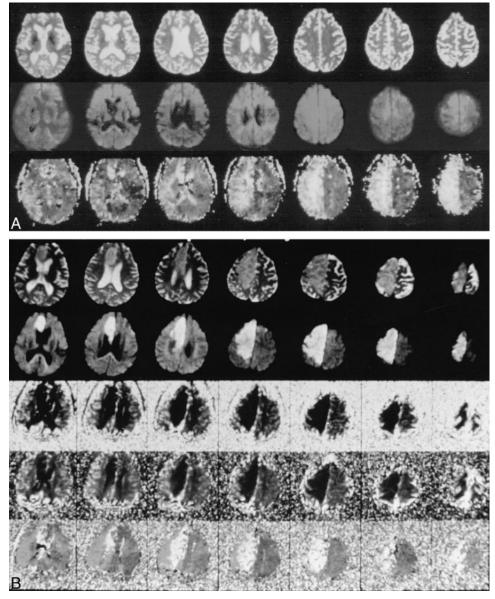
A, T2-weighted (*top*), diffusion-weighted (*middle*), and perfusion-weighted (TTP) (*bottom*) images obtained 2.5 hours after onset of symptoms. T2 and diffusion findings are negative, but profound perfusion abnormality (hyperintensity) of the right hemisphere is shown.
